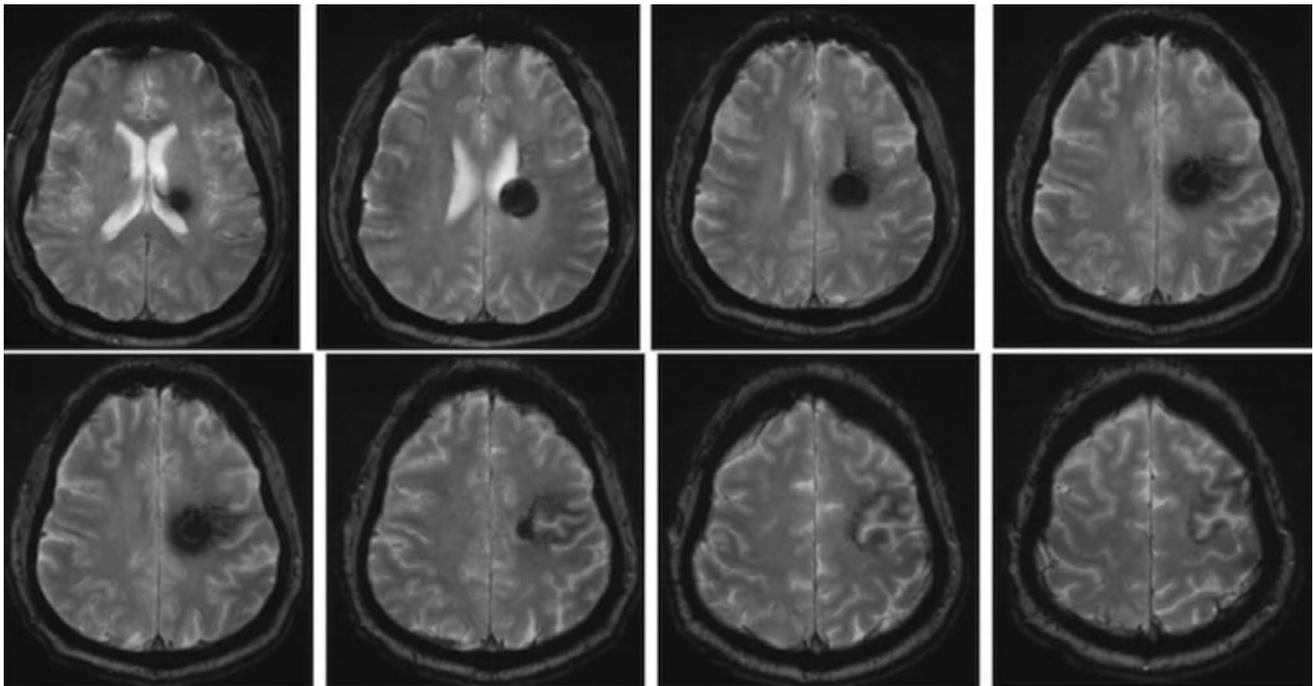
Preoperative axial SWI sequence MRI of a 50 year old right handed male who presented with a first time seizure, and was found to have a periventricular left frontal cavernous malformation anterior to the motor strip
